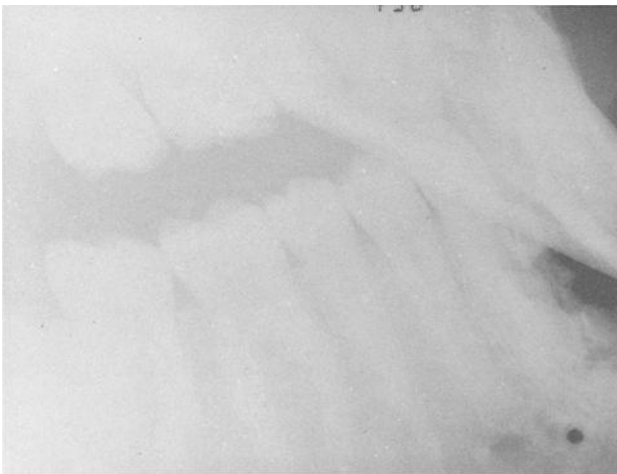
X-radiograph of the right side of the mandible.*
